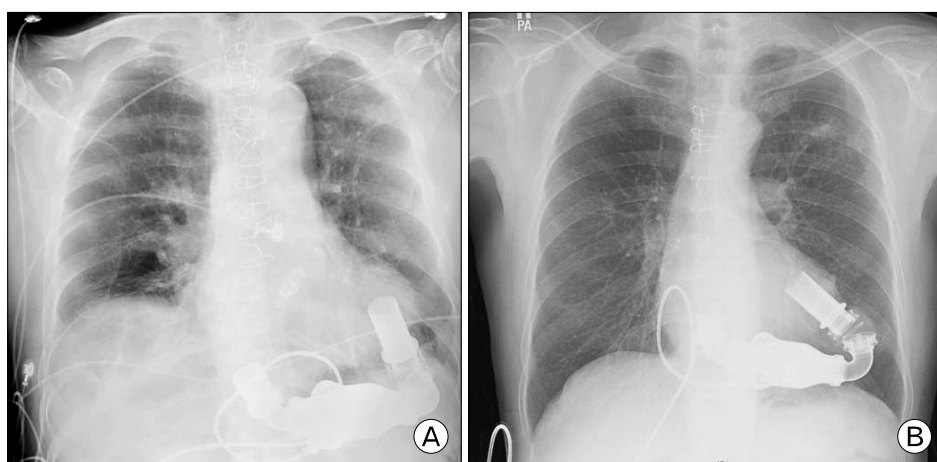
Chest X-ray view after implantation. The successful implantation of the continuous flow left ventricular assist device (HeartMate II) was showed in the figure. First case (A), second case (B).
